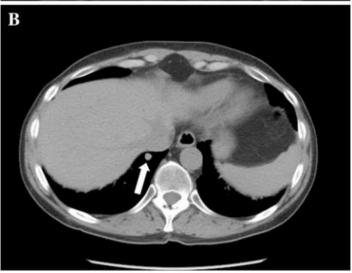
Pituitary MRI showing a 7-mm left paramedian adenoma and slight ipsilateral stalk deviation (a). Chest CT. *Arrow* indicates a small (8×11 mm), contrast-enhanced, apparently non-specific nodule in the right posterior costophrenic excavation (b)
